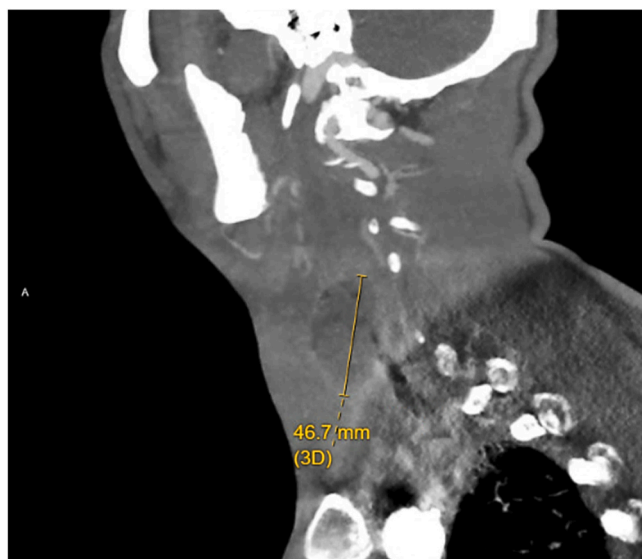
Admission CTA Neck Sagittal View: $3.1 \times 3.0 \times 4.7$ cm abscess enveloping the right Internal Jugular vein at level C4-C5.
